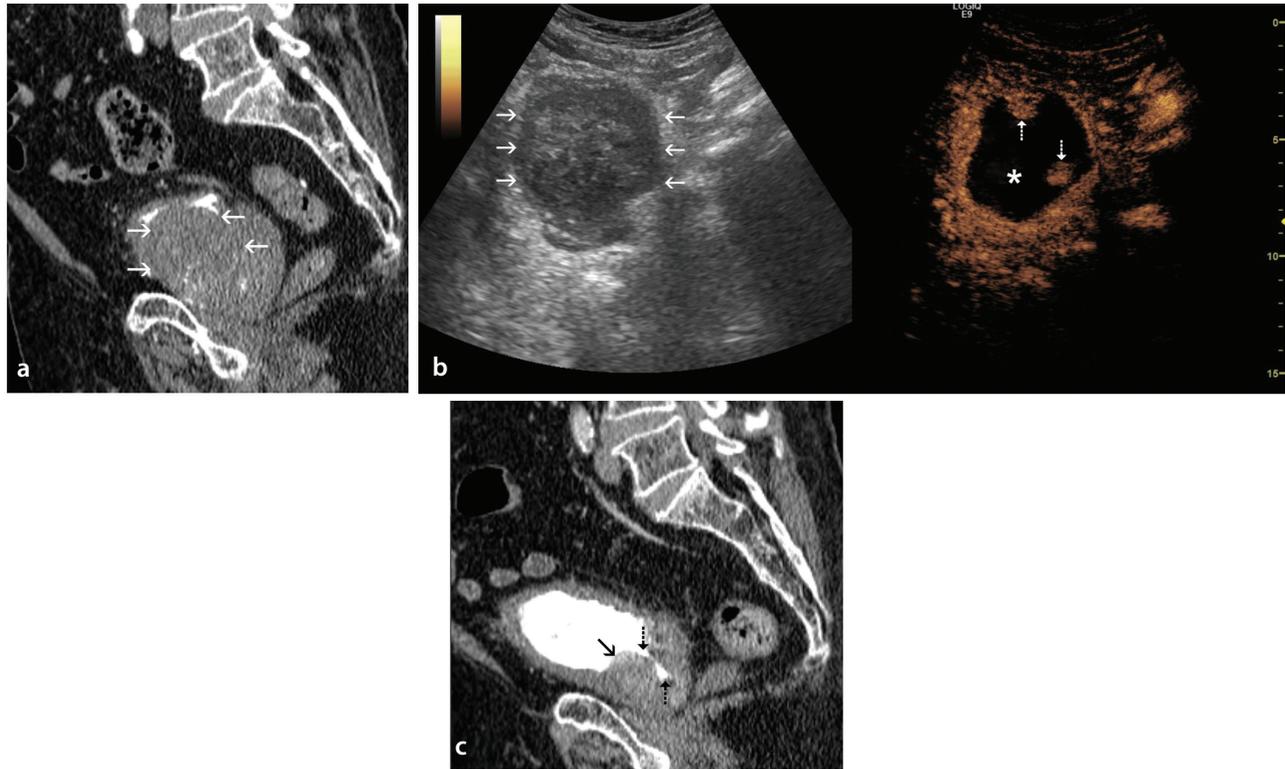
Representative images from a clinically successful case of prostatic artery embolization (PAE) with TGM 40–120. Sagittal reformatted planning computed tomography (CT) image prior to PAE; (a) shows prostatic enlargement and massive intravesical prostatic protrusion (arrows). Axial dual sonographic image obtained 2 days post-PAE (b); with reference gray-scale image on the left showing the bulky intraprostatic protrusion (arrows) and corresponding contrast-enhanced ultrasonography image on the right showing extensive prostatic infarction (*) and minimal residual enhancing tissue (dotted arrows). Sagittal reformatted CT image (c); obtained 12 months post-PAE for an unrelated reason, shows marked prostate shrinkage (arrow) and relief of pressure on the prostatic urethra (dotted arrows).
